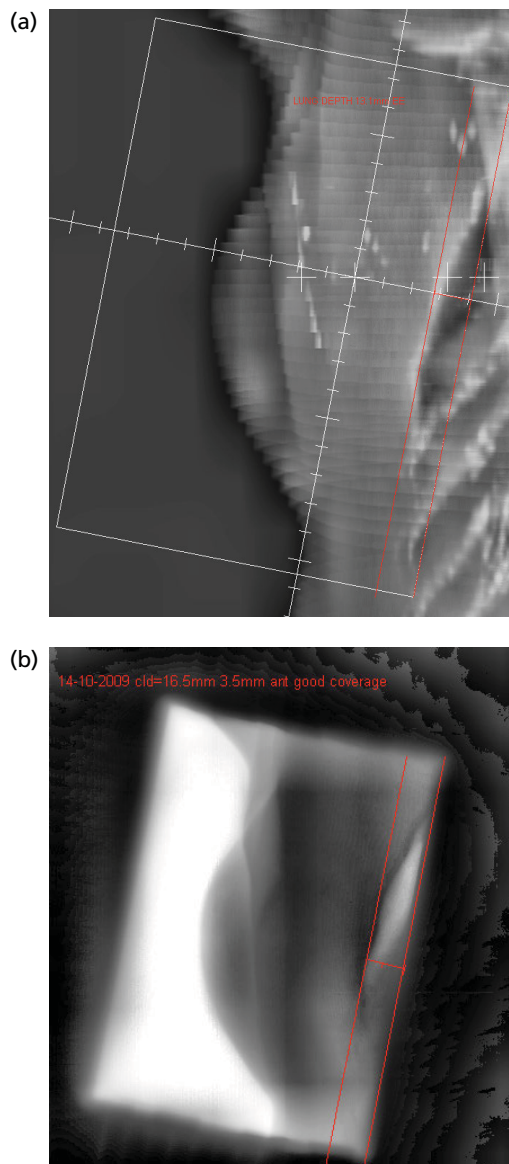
Standard verification technique compares DRR and megavoltage portal image. (a) DRR from planning CT scan; and (b) megavoltage portal image.
